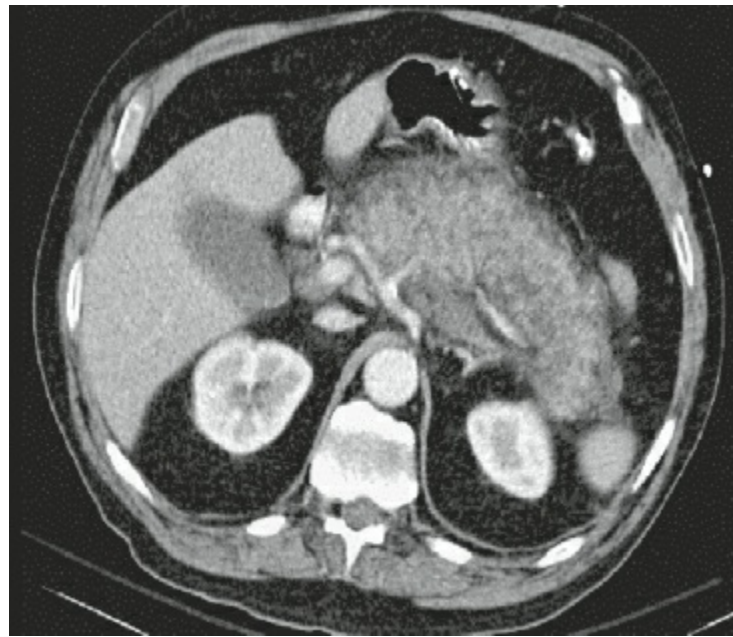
Computed tomography scan of acute interstitial pancreatitis.
